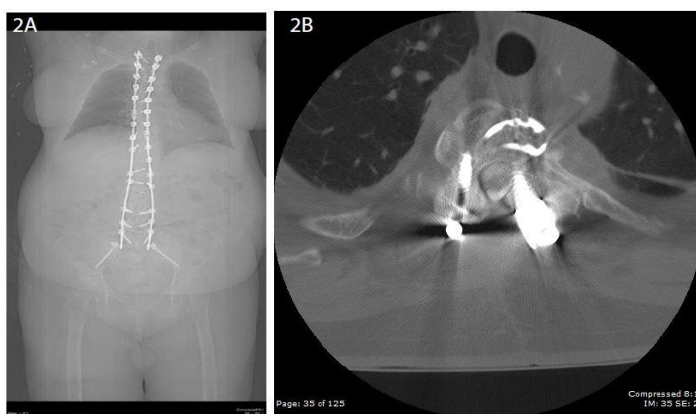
Three month follow up CT thoracic spine (coronal view figure 2a and axial view figure 2b) revealing resolving of moderate to severe central stenosis at the T3-4 level.
